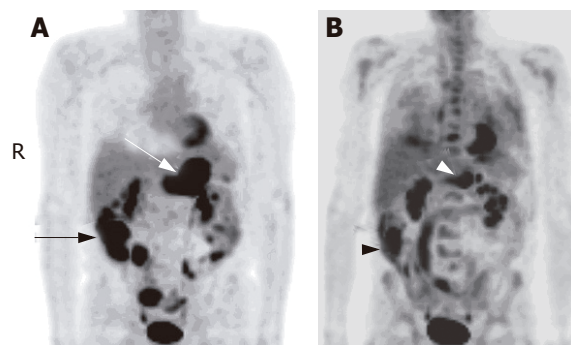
A 68-year-old man with large cell lymphoma. A: Base line ^{18}F -FDG PET scan showed hypermetabolic foci in the stomach (white arrow), cecum and terminal ileum (black arrow), and bowel loops ($\text{SUV}_{\text{max}} = 12.7$); B: ^{18}F -FDG PET scan obtained after therapy showed partial metabolic response of the activity in the stomach (white arrowhead) and cecum (black arrowhead, $\text{SUV}_{\text{max}} = 10.7$).
